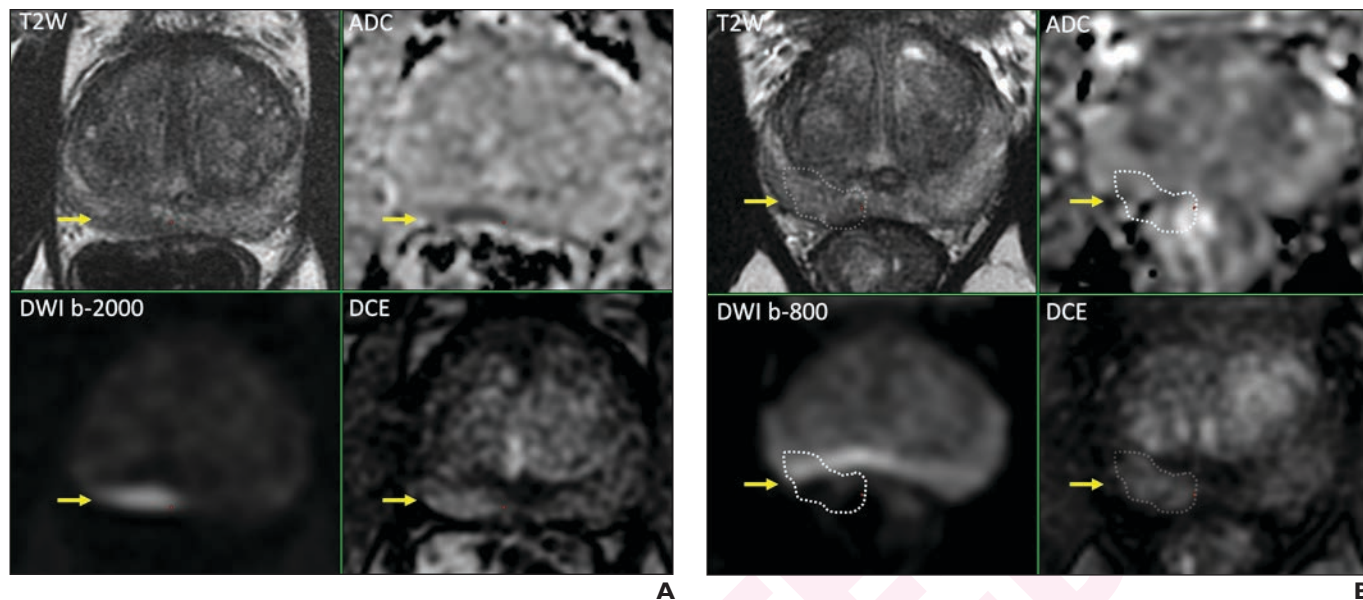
DCE-MRI adds value in non-contrast MRI with insufficient quality. 73 year-old man, cT1, PSA 9.4 ng/ml, Pvmri 56 ml, PSAD 0.18 ng/ml², primary diagnosis. (a) In the right peripheral zone a lesion of 12 mm showed little focal enhancement on DCE, however, not discriminative on T2W, as a result of diffuse low signal of the whole peripheral zone. Owing to air in the rectum, DWI/ADC show artefacts, disrupting the K-space of the peripheral zone. DWI/ADC were not diagnostic for the peripheral zone. (b) Following patient recall, MRI showed a thin subcapsular 12 mm lesion in the right peripheral zone, best identifiable on b-2000/ADC, with focal enhancement. Final score was PI-RADS score 4 (T2W:3, DWI/ADC:4, DCE:+), indicating targeted biopsy. DCE of the first contrast MRI already indicated a suspected lesion in the right peripheral zone. Three MRI-directed fusion biopsies revealed Gleason score 3+4=7 (ISUP grade 2) without cribriform / intraductal growth, in all three biopsies.
